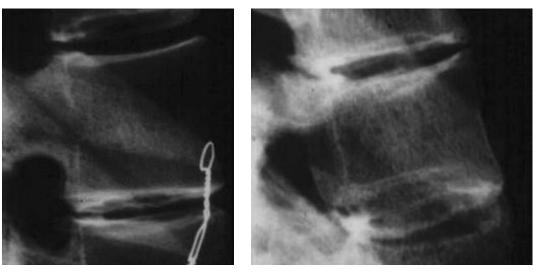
Progressive asymmetrical wedging with growth. True lateral X-ray films of the apical vertebra of different-size curves. (A) Curve of 20 degrees with reasonable sagittal shape. (B) Curve of 40 degrees, showing that the back and inferior surfaces of the vertebral body are ellipsoid. (C) Curve of 80 degrees, showing marked asymmetrical vertebral wedging.
